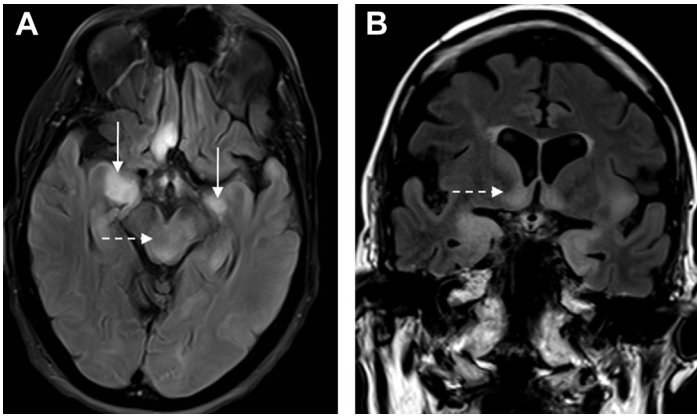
Anti-Ma encephalitis from testicular tumors in a 29-year-old man. Axial (A) and coronal (B) FLAIR images show asymmetric hyperintensity in the medial temporal lobes (arrows), midbrain (dash arrow in A), nucleus accumbens (dash arrow in B), and paraterminal gyrus.
